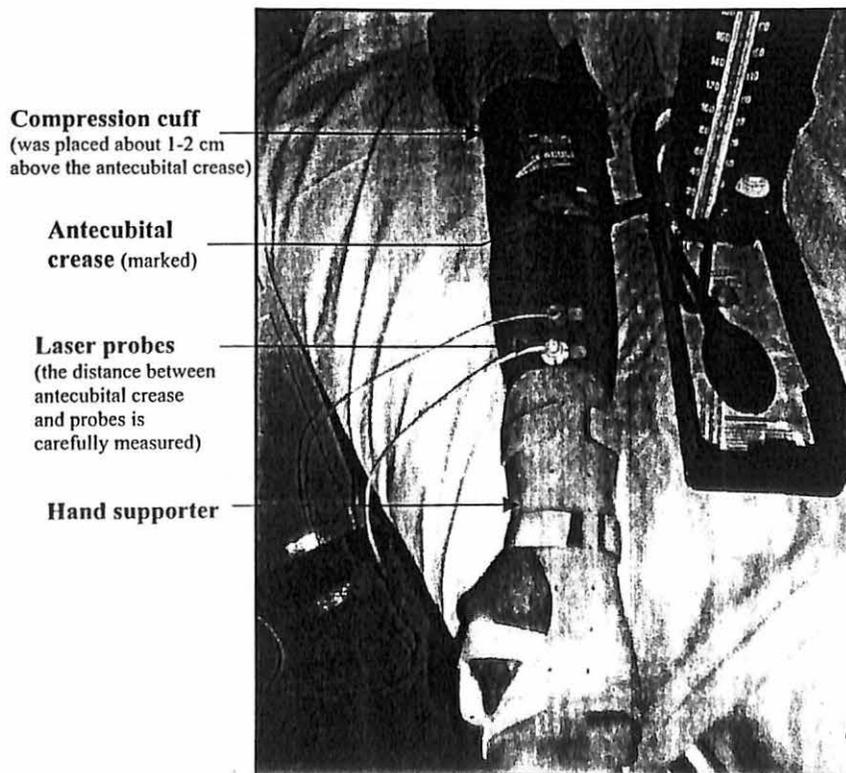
Placement of laser Doppler probes, hand supporter, and compression cuff on a participant's right arm.
